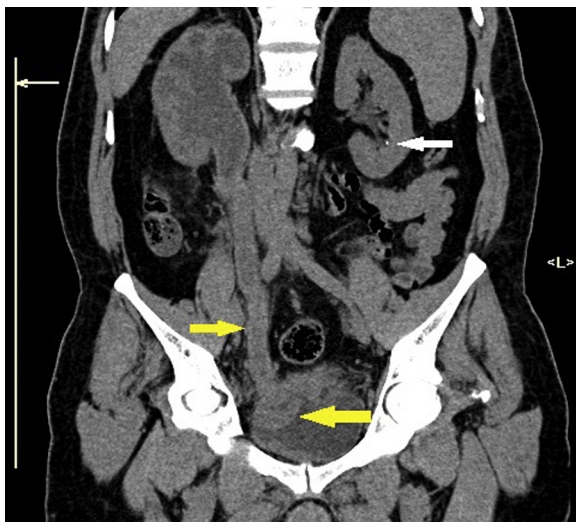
Sixty-one year old male patient with right flank pain and hematuria. CT stone protocol shows urinary bladder mass at the right vesico-ureteric junction (large yellow arrow) with obstruction of the right ureter, which is filled by mass tissues (small yellow arrow). Small lower calyceal stone was found in the left kidney (white arrow).
